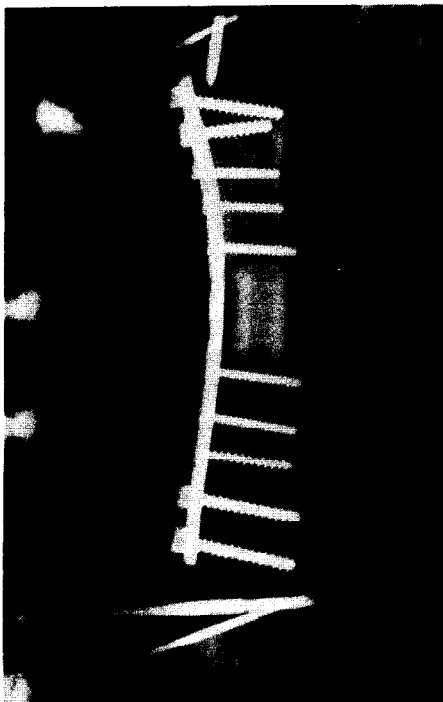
Tubular apatite artificial bone implanted in femur, radiograph, 6 weeks postop.
